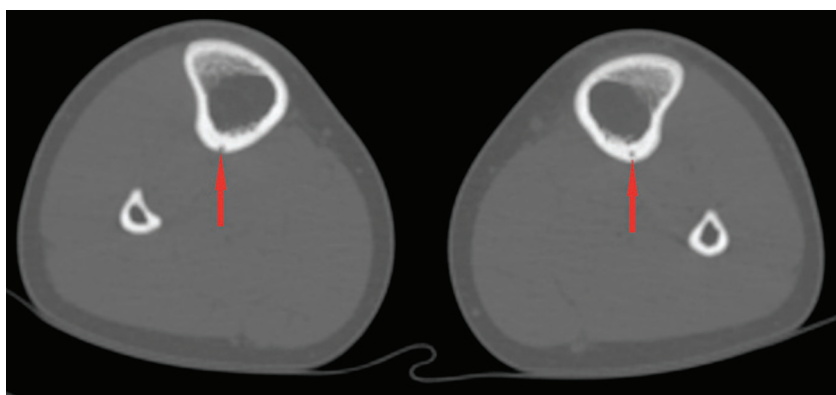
Axial CT through the proximal third of the bilateral tibias showing the normal posterior nutrient foramina of the tibia (arrows).
